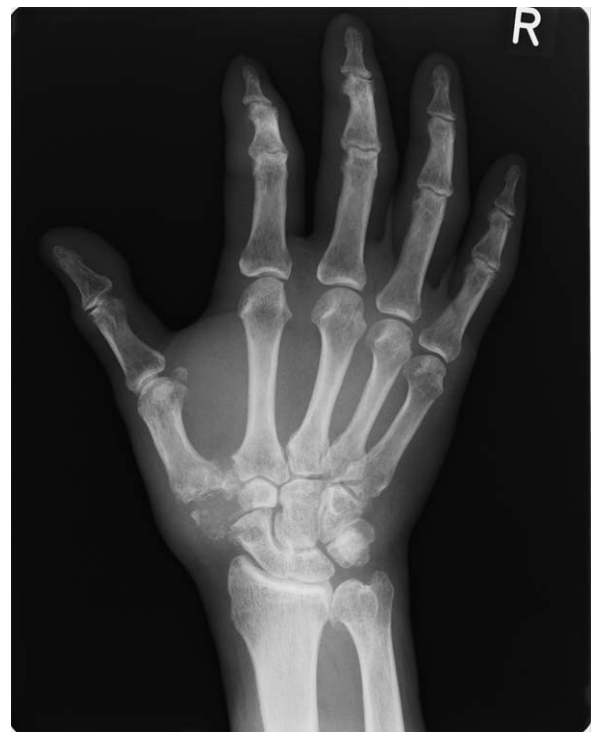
X-ray image of the right hand at the initial visit. The patient had an osteolytic lesion in the trapezium.
